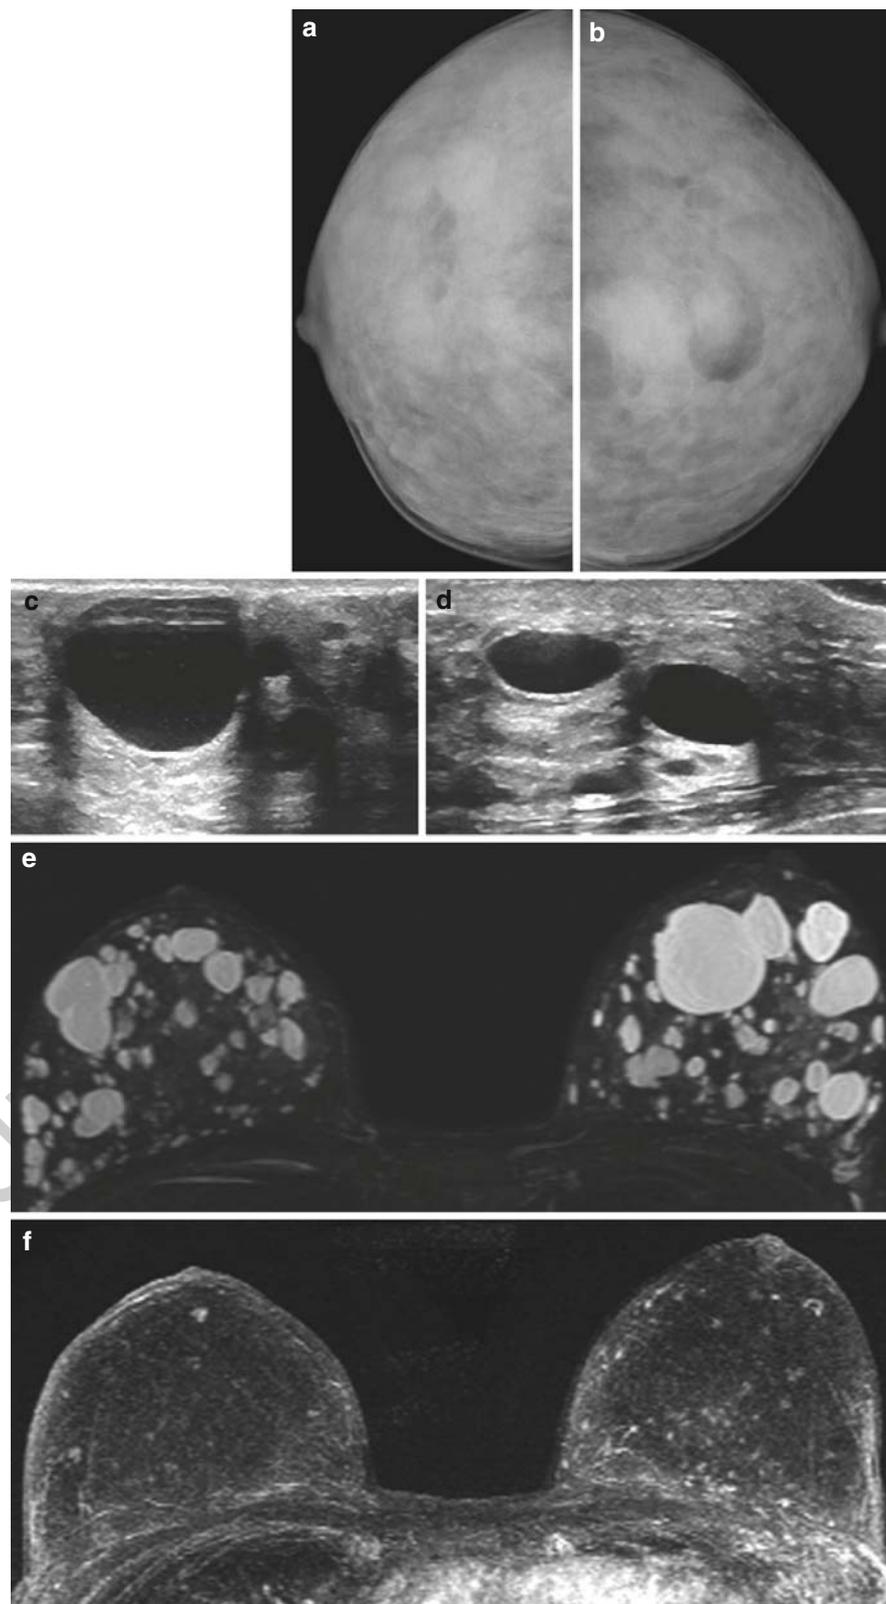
MRI in a patient with extreme fibrocystic changes. Digital mammography in CC view shows extremely high density type IV according to the American College of Radiology and clearly reduced sensitivity (a, b). Multiple micro- and macro-cysts in both breasts on ultrasound (c: right breast, d: left breast). Demonstration of the multitude of cysts in both breasts in the MIP presentation of water-sensitive IR images (e). High reliability for the detection of breast cancer in the MIP of the MRI subtraction images demonstrating only few small foci (MRM-density type I)
